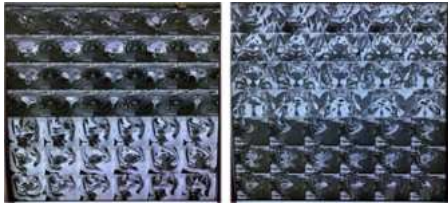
MRI-Pelvis of T1 hyperintense and T2 hypointense lesion
